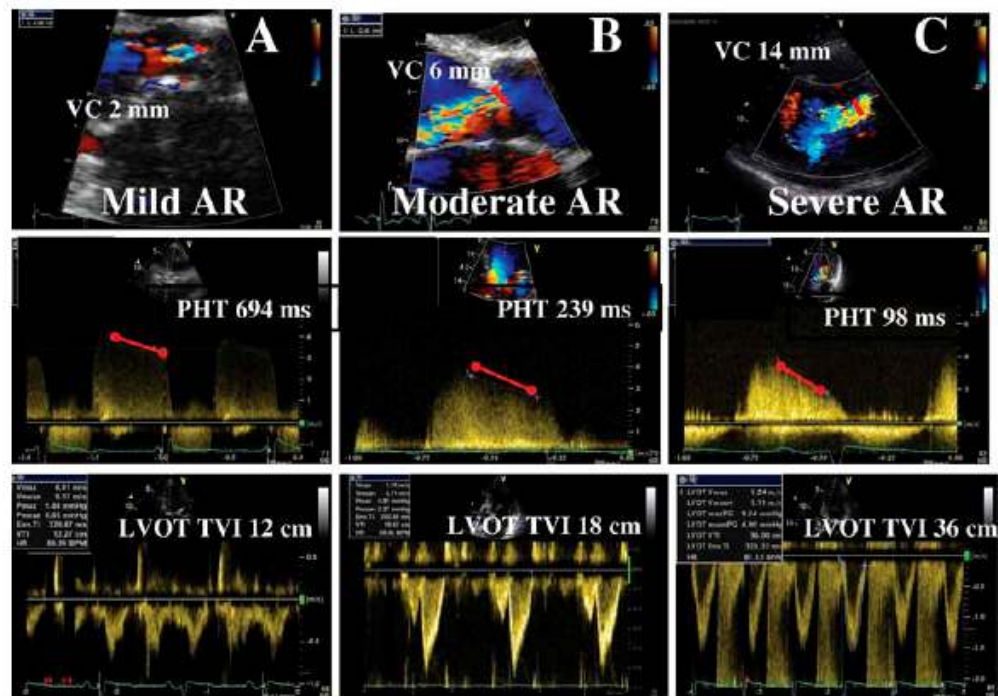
Three examples of aortic regurgitation (AR) are provided, all taken from the parasternal long-axis view using colour Doppler (top) and from the apical five-chamber view using continuous-wave Doppler (mid). The vena contracta (VC) increases with the severity of AR. The pressure half-time (PHT) decreases with more severe AR, whereas the left ventricular outflow time–velocity integral (LVOT TVI) increases.
